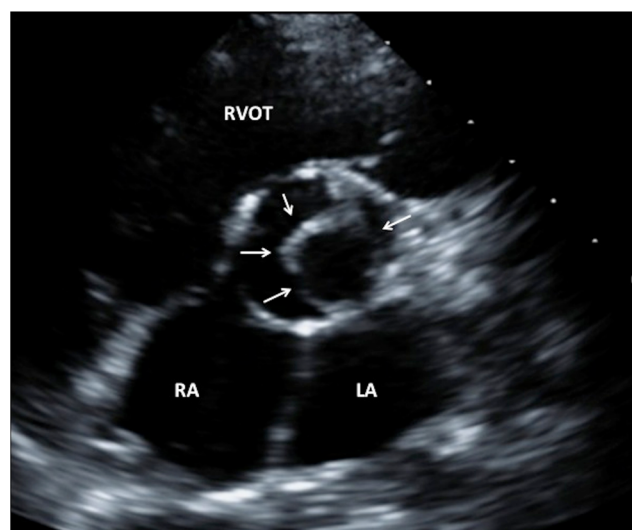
Parasternal short-axis view of young adult with a unicuspid AV. Note the “keyhole” appearance with an open commissure between the non and left coronary cusps (arrows) (LA left atrium, RA right atrium, RVOT right ventricular outflow tract)
